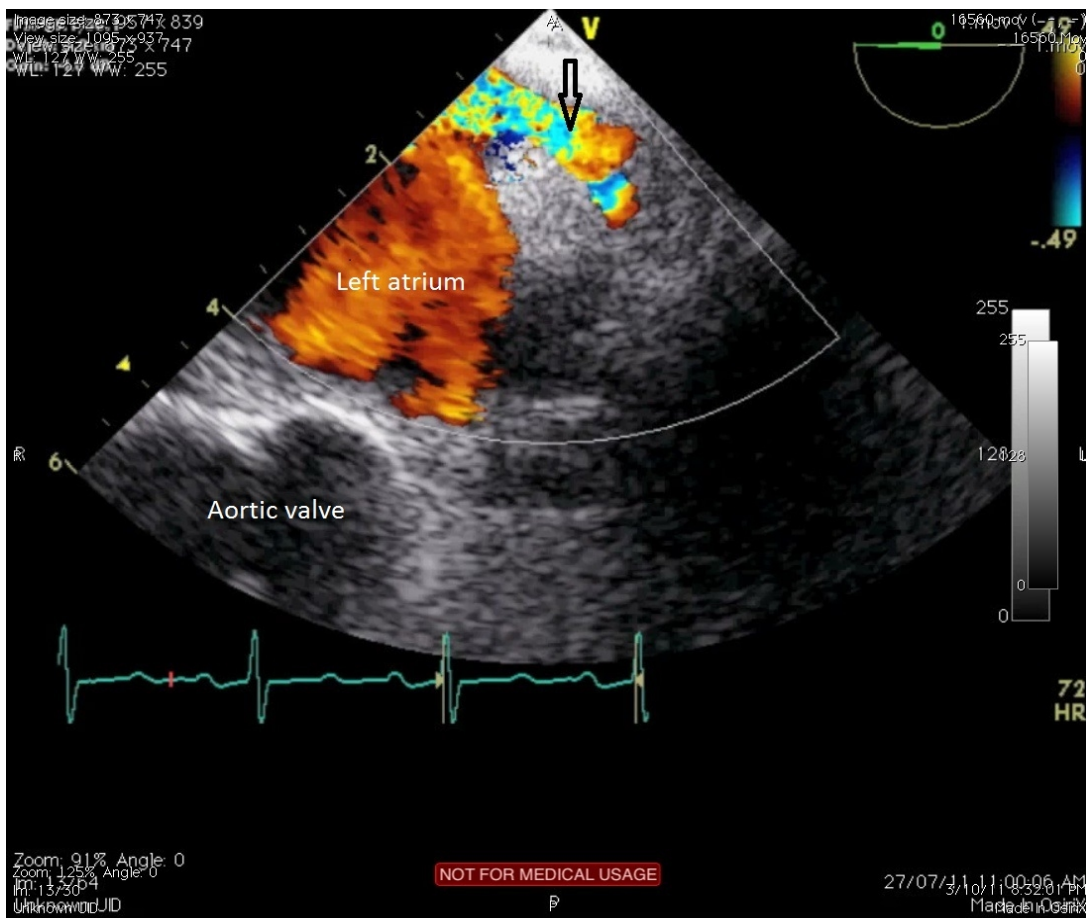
Transesophageal echocardiogram with color Doppler showed the confluence of the left upper and lower pulmonary veins entering the left atrium. There is a turbulent, continuous flow (arrow) into the left atrium originating from a discrete stenosis at the left pulmonary veins
